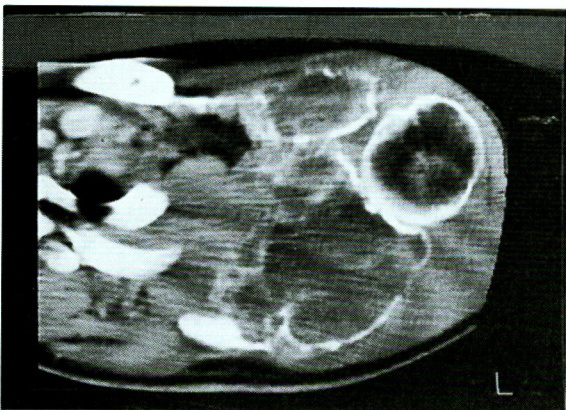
Computed tomography showed an expansile mass with multiple internal septations. There were fluid levels within the multiple cysts.
